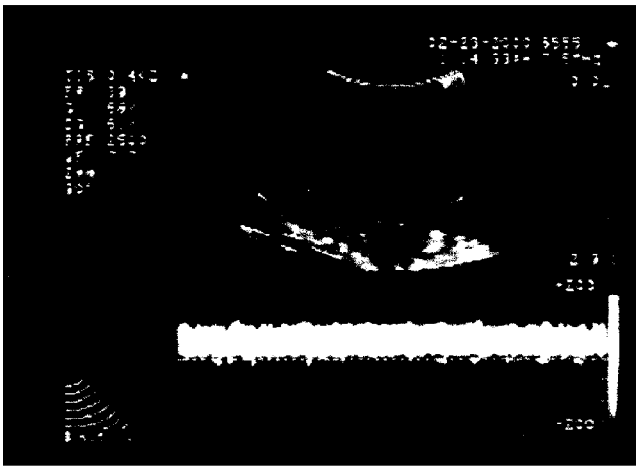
Measurements of hepatic venous blood flow by laparoscopic Doppler ultrasound (a) Normal blood flow signal; (b) hepatic venous flow signal almost disappeared after balloon inflation.
